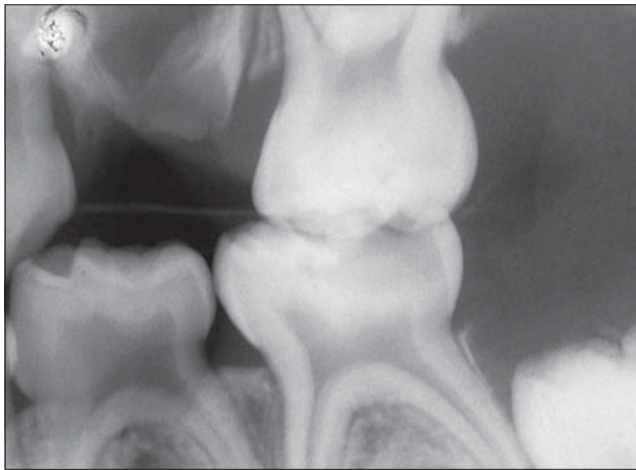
Case A; a preoperative bitewing radiograph of an asymptomatic mandibular left second primary molar with deep carious dentin.
